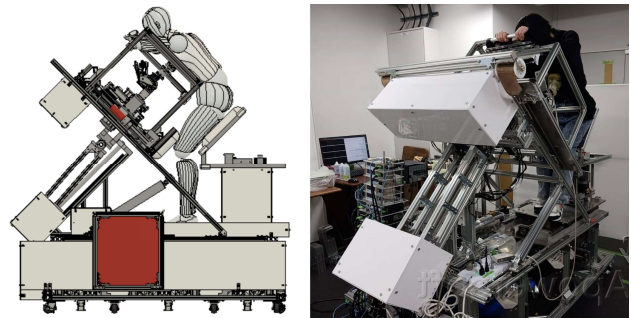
Seated-style echocardiography robot
